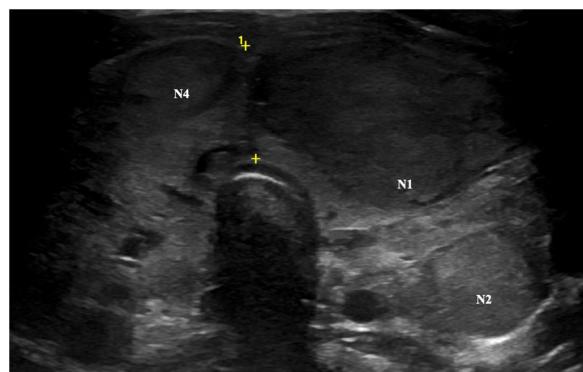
The patient's thyroid ultrasound scan. In this cross section, N1, N2 and N4 can be seen.
